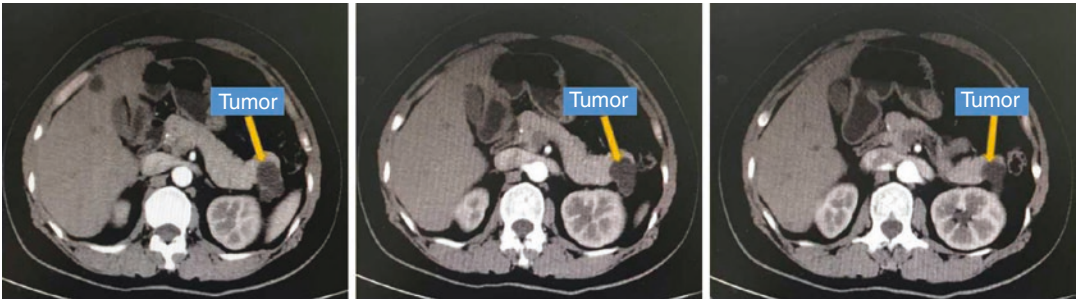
CT image showed a mass in the tail of the pancreas
